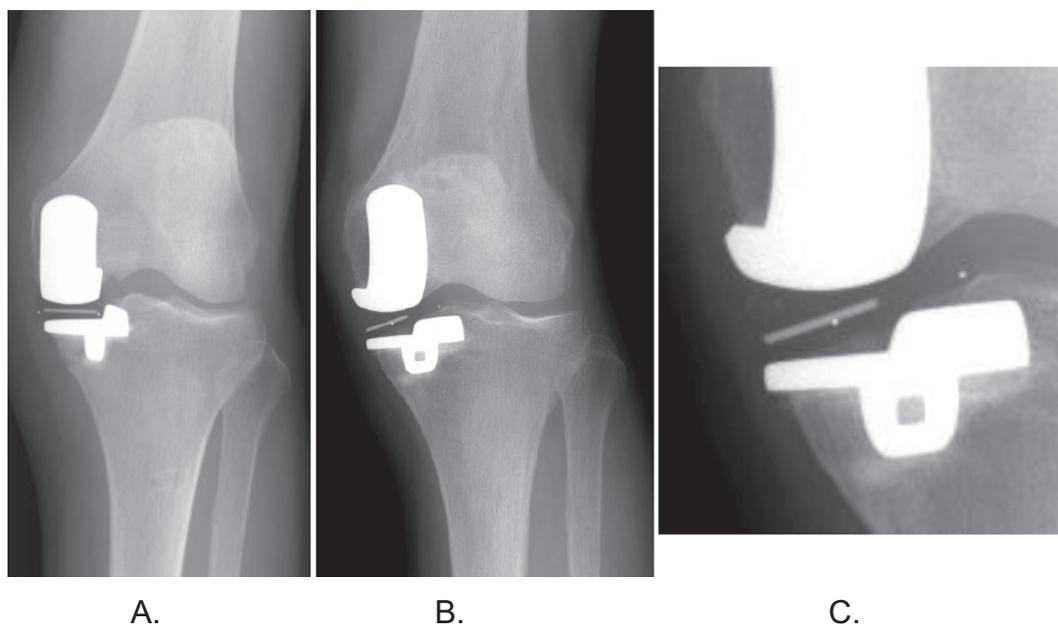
Case 1 radiographs. (A) Postoperative plain radiographs of the left knee (anteroposterior view); (B) plain radiographs when the bearing dislocated into the intercondylar ridge; (C) enlarged radiographs of the bearing with bearing dislocation into the intercondylar ridge.
